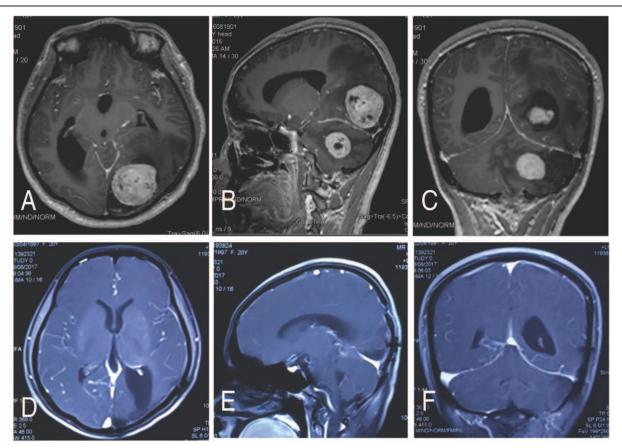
Preoperative and postoperative brain magnetic resonance imaging (MRI). Preoperative contrast-enhanced MRI (Gd-diethylenetriamine pentaacetic acid) showed 2 enhanced lesions, located at left occipital lobe and the left cerebellar hemisphere (A, axial view; B, sagittal view; and C, coronal view). MRI examination at 10 months after the operation showed no residual tumor or signs of recurrence (D, axial view; E, sagittal view; and F, coronal view).
